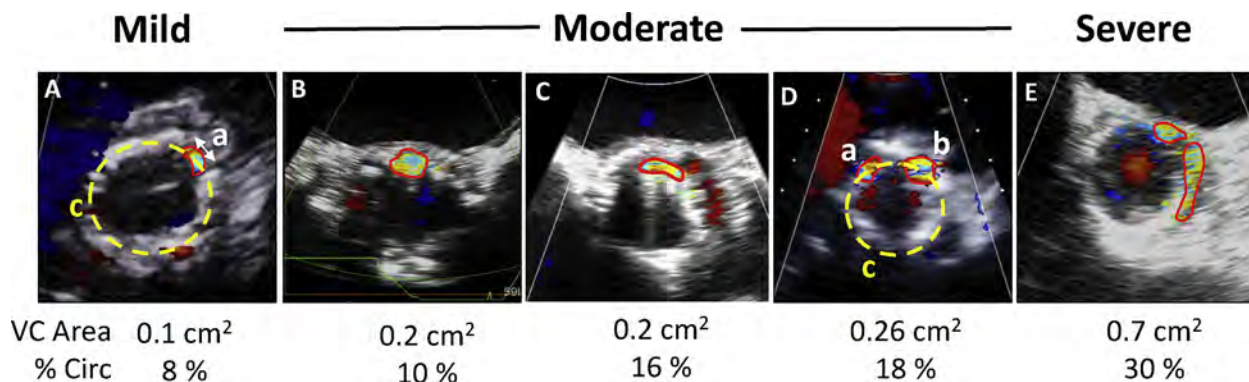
Examples of paravalvular regurgitation of different degrees of severity using short-axis color Doppler depicting two criteria: vena contracta area (VCA), and % circumferential (Circ) extent of the jet in relation to the total circumference of the prosthetic valve ring. % Circ is calculated as the length of the jet along the valve curvature (“a” in Panel A) divided by the total perimeter (“c” in panel A) as: $(a/c) \times 100$. In the case of two jets (D), % Circ would be $[(a + b)/c] \times 100$. As the VCA and circumferential extent of the jet increase, AR severity is more significant. However, VCA in TAVR is affected by both circumferential extent and thickness of the PVR, i.e., separation of the valve from the aortic wall. As shown in Panels A and B, the circumferential extent may at times be similar to those of mild regurgitation but the thickness of the PVR is large, leading to a larger VCA (B). Similarly, Panels B and C depict two lesions of similar moderate severity by VCA but different circumferential extent. These considerations are very important in assessing mild and moderate AR severity and multiple jets (A-D). Once circumferential extent exceeds 30%, PVR is usually severe.
